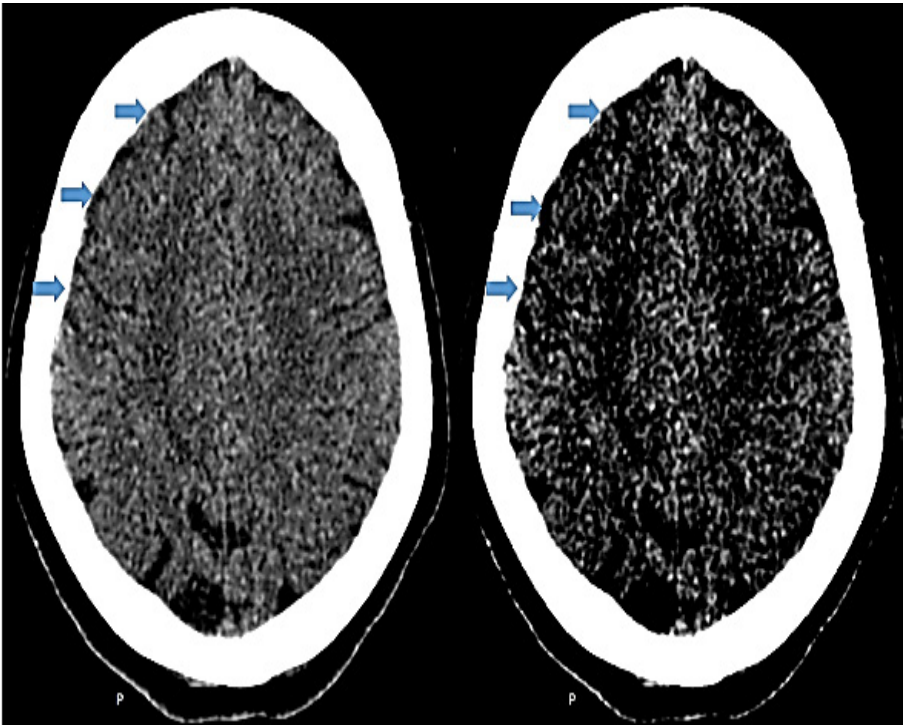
Non-contrast CT brain of a patient with an acute right MCA stroke.
